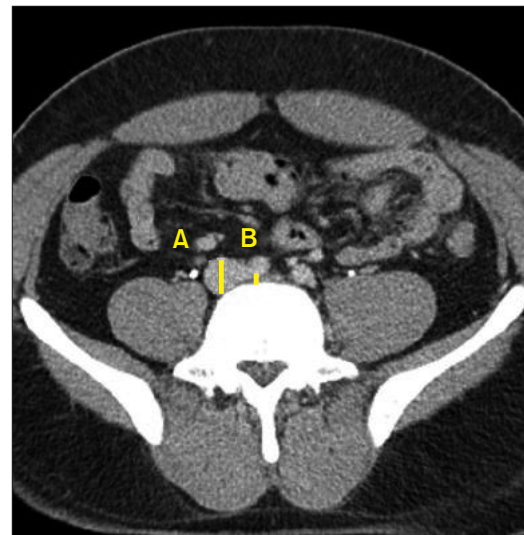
Axial view on computed tomography scan of a patient with May-Thurner syndrome. Diameter ratio was defined as the diameter of the stenotic iliac vein (B) divided by the diameter of the contralateral iliac vein (A).
